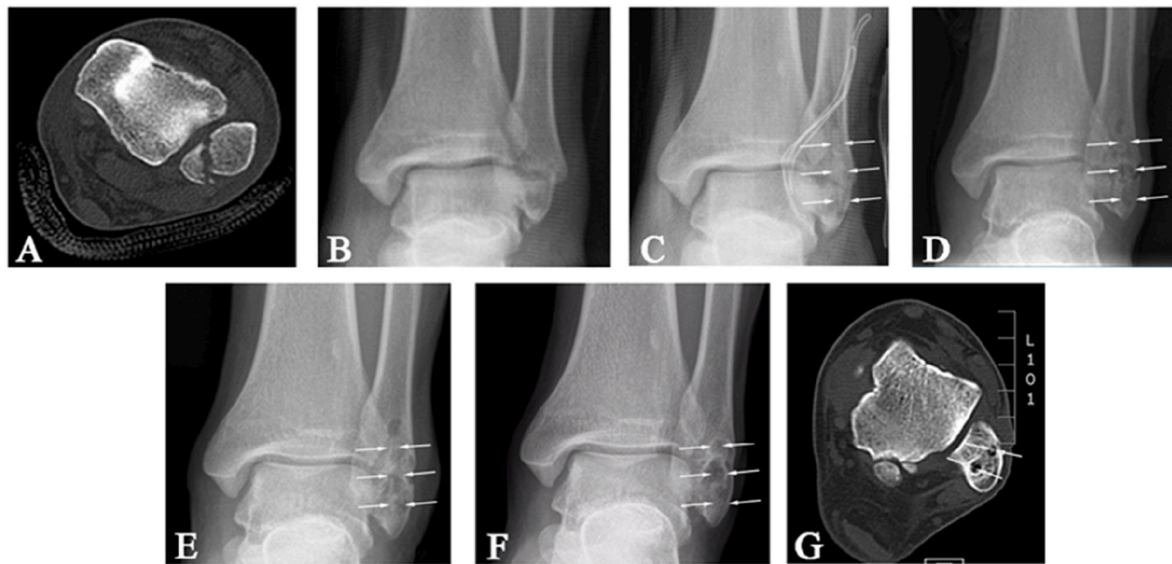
Preoperative and postoperative radiographs of a 31-year-old man patient with left Lateral malleolar fracture. (A–B) image of the patient before operation; (C) the fracture was fixed with two bioabsorbable high pure Mg screws; (D) the fracture healed 24 weeks postoperative; (E) the radiolucent zone decreased significantly 92 weeks postoperative; (F–G) The degradation of high pure Mg screws were almost completed 152 weeks postoperative. The radiolucent zone was non-mineralized bone tissue surrounded by osteosclerotic zone.
